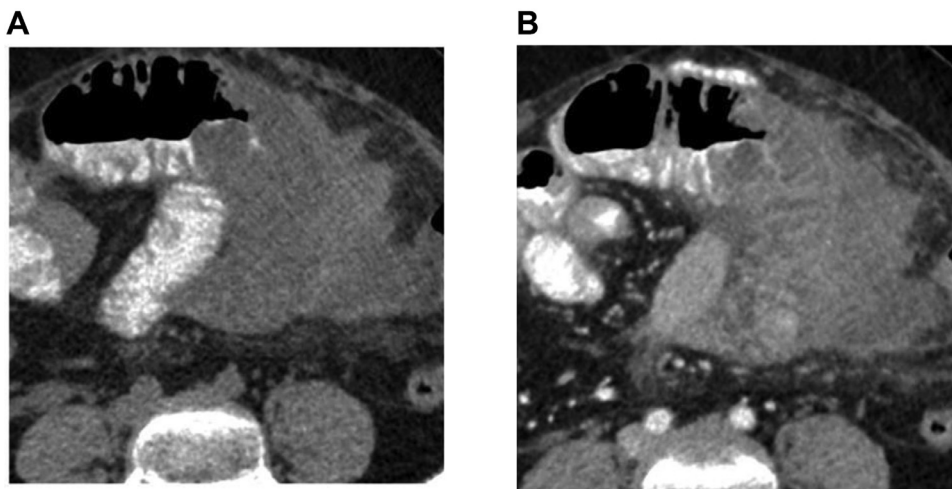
Axial plain (A) and contrast enhanced CT images (B) show the mesenteric lesion abutting the serosal aspect of adjacent jejunal bowel loop. The jejunal loop shows edematous mucosal folds with thickened, enhancing walls and reduced luminal calibre.
